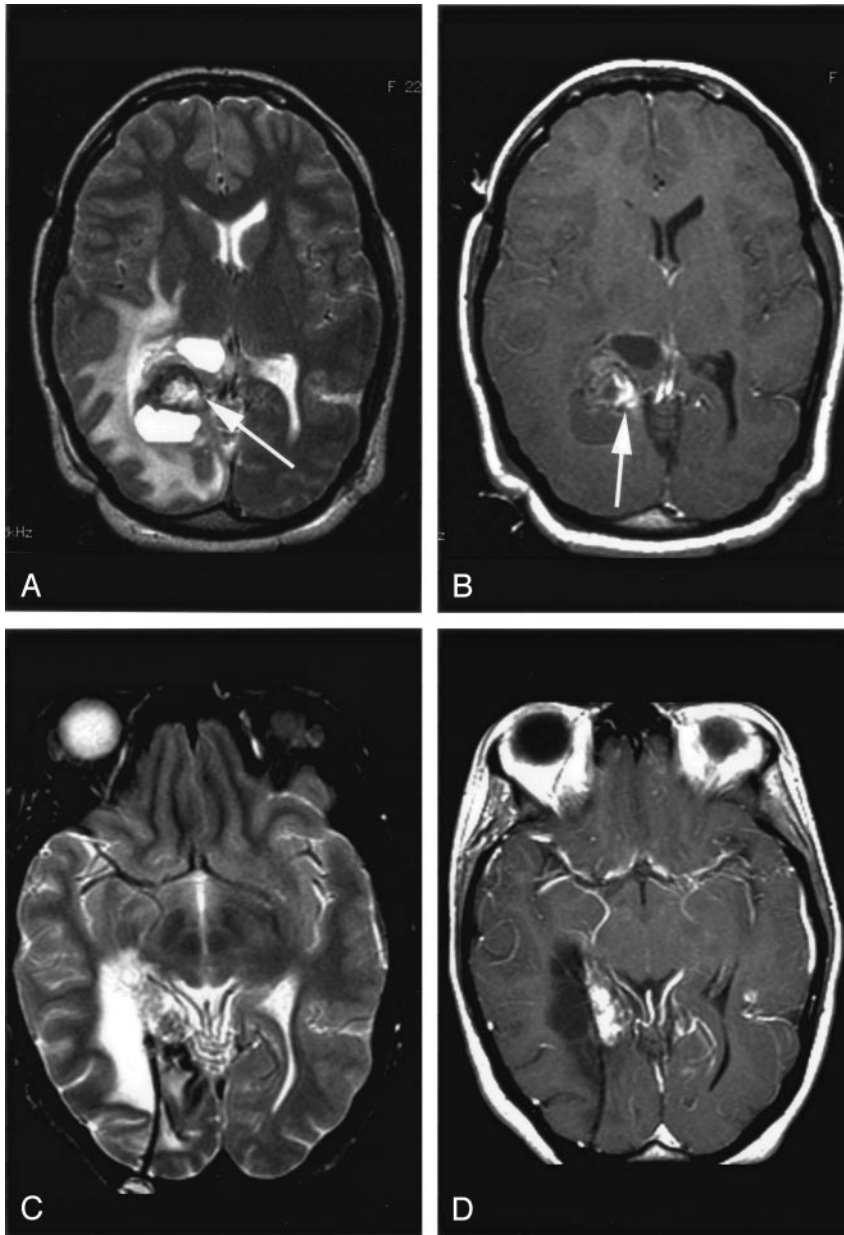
MR image obtained 34 months after AVM ablation.
